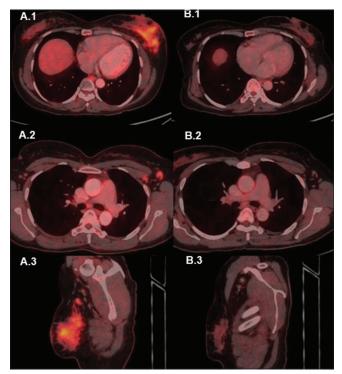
A 39-year-old female was diagnosed with carcinoma left breast – cT3N1M0, estrogen receptor-negative, progesterone receptor-negative, and human epidermal receptor 2 neu positive (HER2neu enriched type). She was planned for neoadjuvant chemotherapy and received six cycles of 3-weekly paclitaxel, cyclophosphamide, and trastuzumab. The initial staging positron emission tomography-computed tomography (PET-CT) images show fluorine-18 fluorodeoxyglucose accumulation in the primary lesion in the left breast (A.1) and left axillary nodal disease (A.2). Similar findings are depicted in the sagittal section (A.3). The postchemotherapy PET-CT showed complete resolution of metabolic activity in the primary lesion (B.1) and left axillary nodes (B.2) and also depicted in sagittal images (B.3]). The PERCIST grading and NIMS grading system (Grade 4) both are suggestive of complete metabolic response
